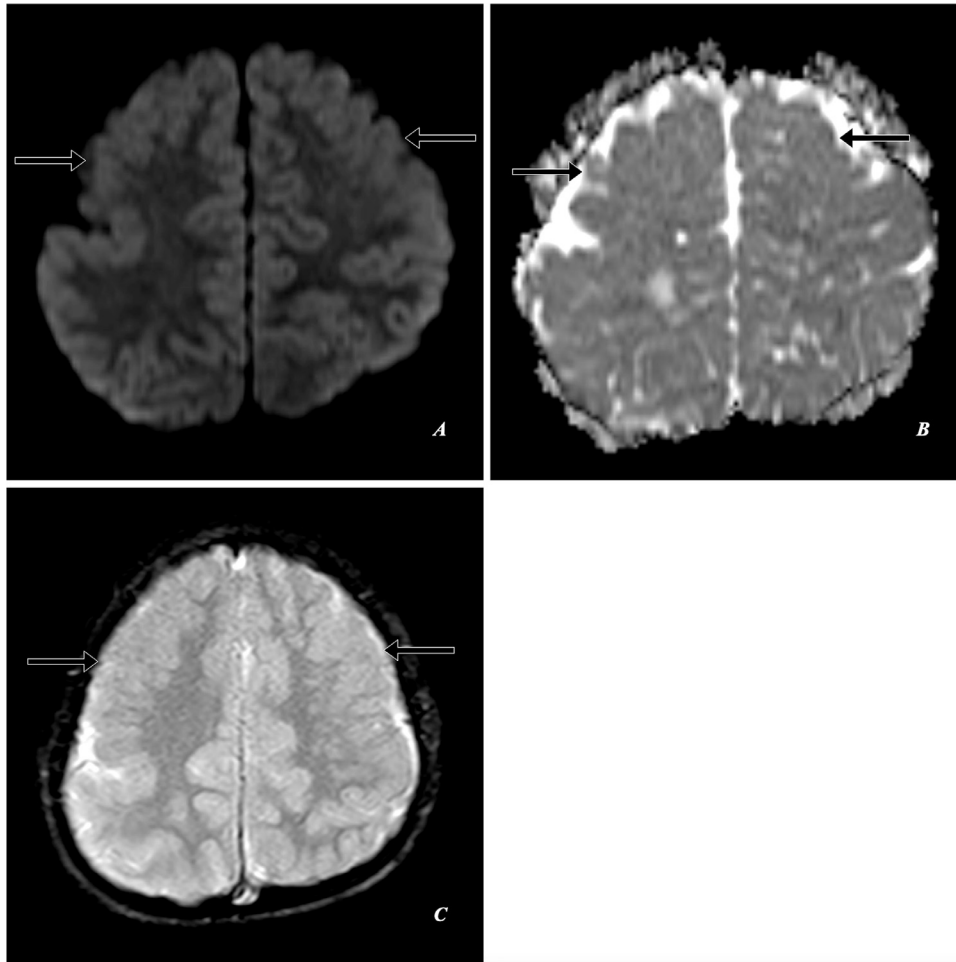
(A-C): A 6-year-old female was referred to a neurology clinic due to severe developmental delays, hypotonia, and recurrent intractable seizures. Magnetic resonance imaging (MRI) of the brain shows thick cortices in the bilateral high frontoparietal lobes (predominantly in bilateral high frontal lobes) with micro-lobulated or multi-nodular gyri/surface of the “Pebbly/Cobblestone complex” with sparse cortical sulci (A) Diffusion-weighted image (DWI) - no reduced diffusivity, (B) Apparent diffusion coefficient (ADC) - no signal change, (C) Gradient (GRE) - no blooming (arrows).
